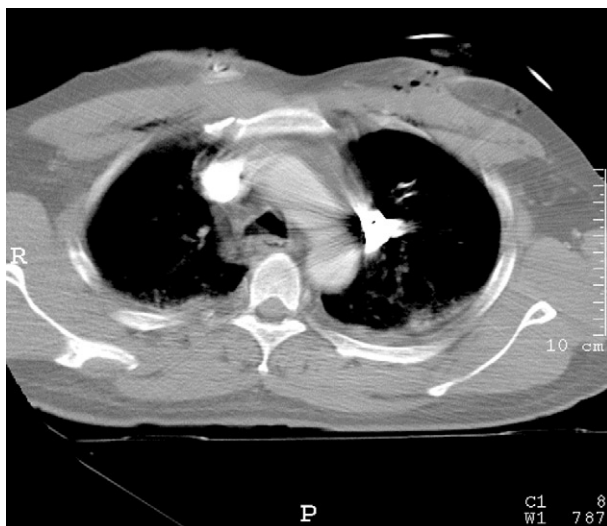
Computed tomography scan of 45 year-old man with penetrating rubber-bullet injury of left chest
